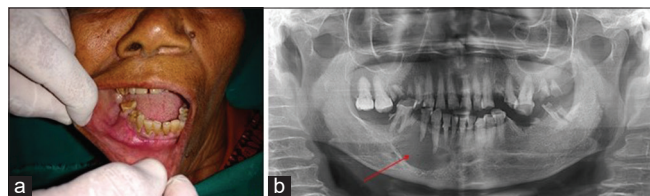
(a) Preoperative clinical picture showing expansile bony swelling obliterating the buccal vestibule on the right side of the mandible. (b) Preoperative orthopantomogram showing unilocular radiolucent lesion in relation to periapical region of rootstump - 45, grossly attrited 44 in the right parasymphysis region of the mandible
